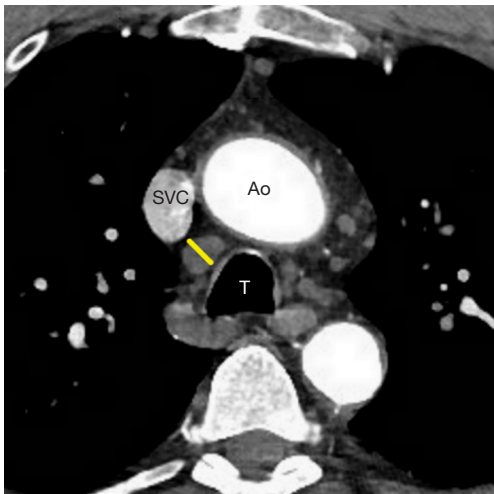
Computed tomography angiography, which demonstrates a normal right lower paratracheal lymph node. The lymph node was measured in the short axis (yellow line). Ao, aorta; SVC, superior vena cava; T, trachea.
